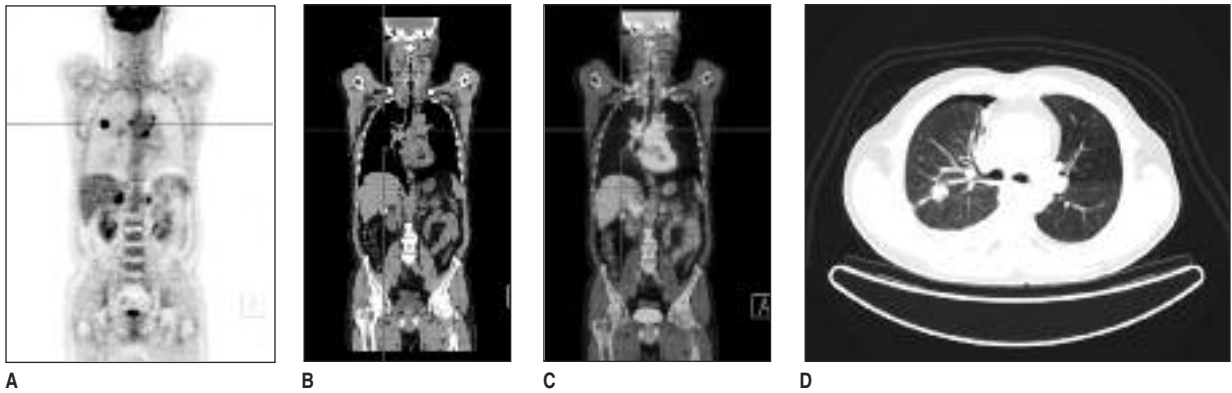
For primary lung cancer staging, 54 year old man was referred to our department. Whole body images were obtained 60 minutes after intravenous injection of 380 MBq (10,2 mCi) F-18 FDG on a Siemens Biograph LSO HI-REZ integrated PET/CT camera. CT scan was done for attenuation correction and defining anatomical landmarks. The coronal PET (A), coronal CT (B) and coronal fusion (C) images showed high-grade uptake in the right lobe of lung and bilaterally metastatic intense FDG uptake in mediastinum, supraclavicular lymph nodes and in suprarenal glands. Right upper lobe mass can be seen in Thorax CT image (D).
